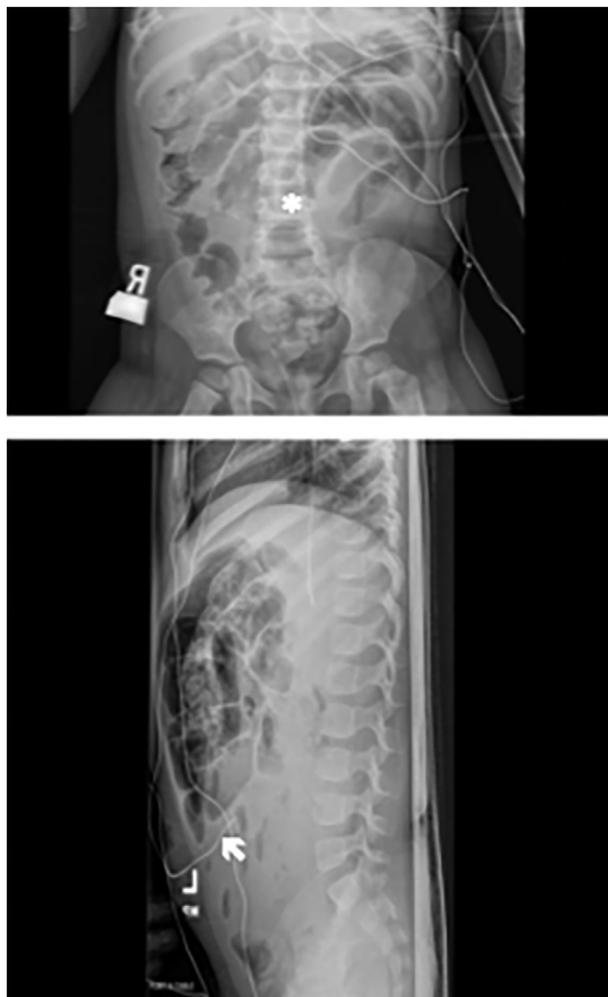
Posterior-anterior and cross-table lateral radiographs of the abdomen demonstrating mildly distended loops of bowel (*) and air-fluid levels (white arrow).
